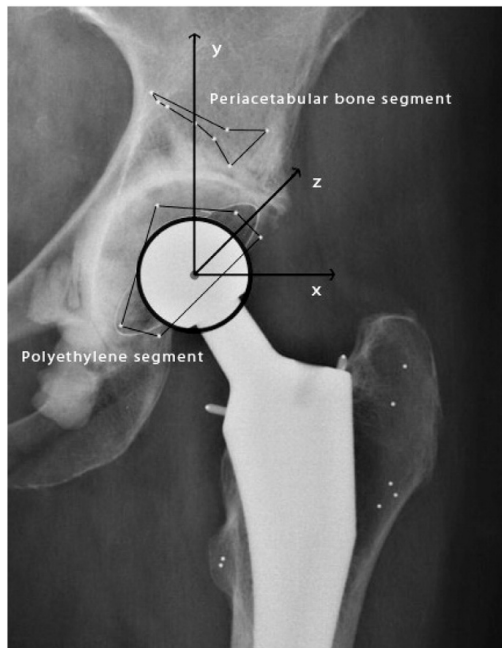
X-ray of a THR with tantalum markers in the periacetabular bone (periacetabular bone segment) and the cemented cup with tantalum markers (polyethylene segment). In the present study point motion of the center of the head is estimated according to the segments described above.
